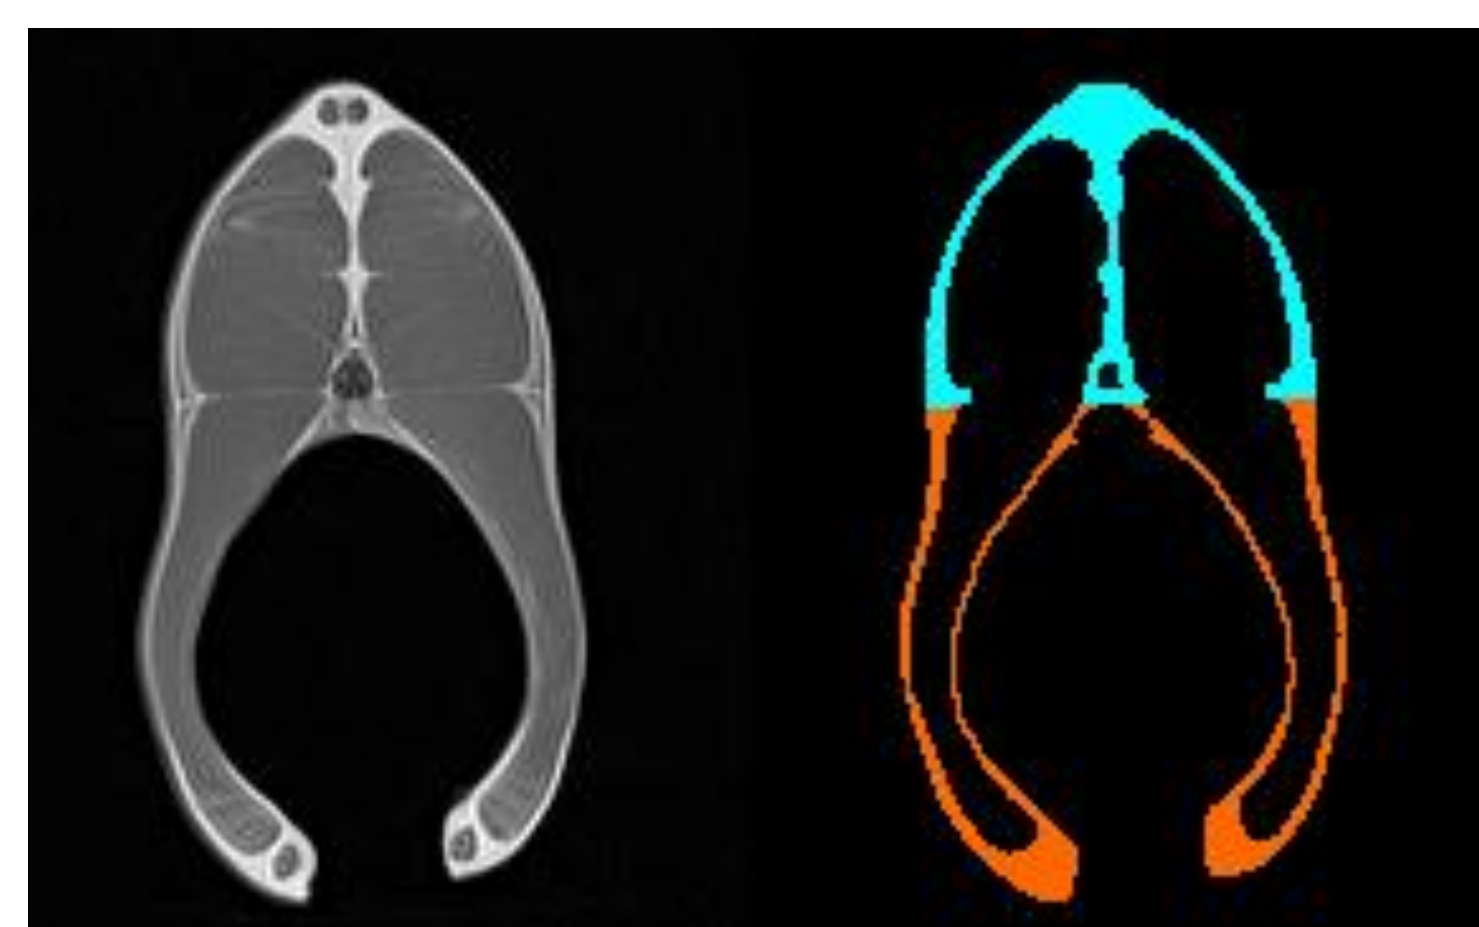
MRI image on the left, ventral and dorsal subcutaneous fat on the right
